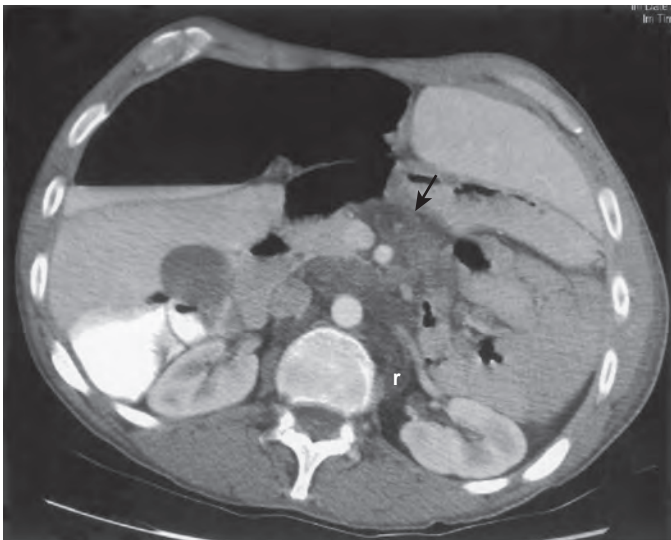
Lymphadenopathy in celiac disease. This CT scan shows numerous low-attenuation lymph nodes (arrow) in the root of the small bowel mesentery and in the retroperitoneum (r).
